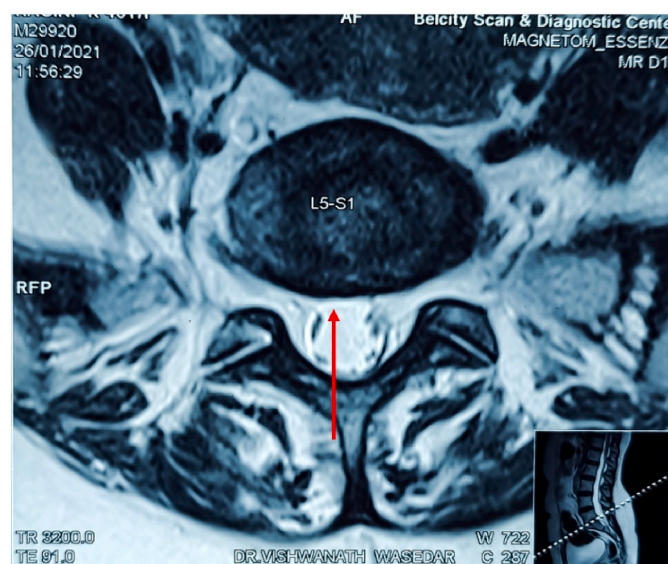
The red arrow in axial view of the T2-weighted image shows complete interval resolution of L5-S1 disc sequestration and no significant neurologic compression.
